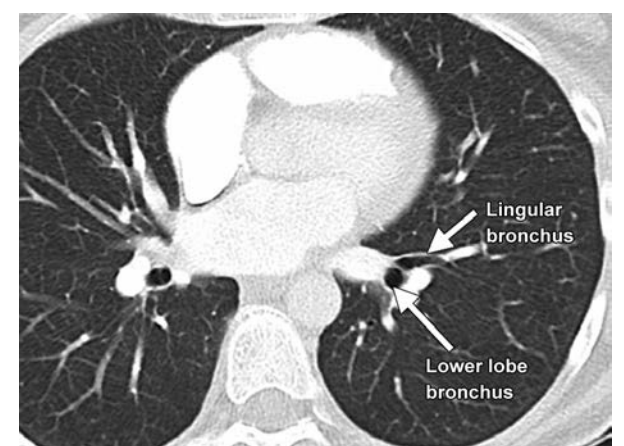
CT chest showing the origin of the lingular and left lower lobe bronchus
